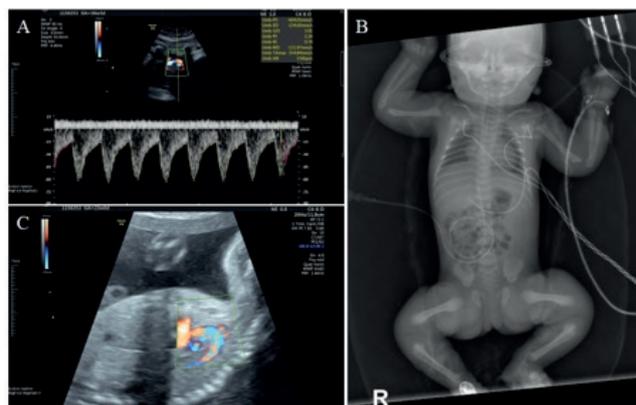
Echocardiography, X-ray, and prenatal ultrasonography of the patient were taken before and after birth. A) Atrioventricular Septal Defect (AVSD) was detected in Echocardiography. B) Abnormal extremities were shown in vertebra, lower and upper extremity radiography. C) Uterus didelphys anomaly was observed in USG.
